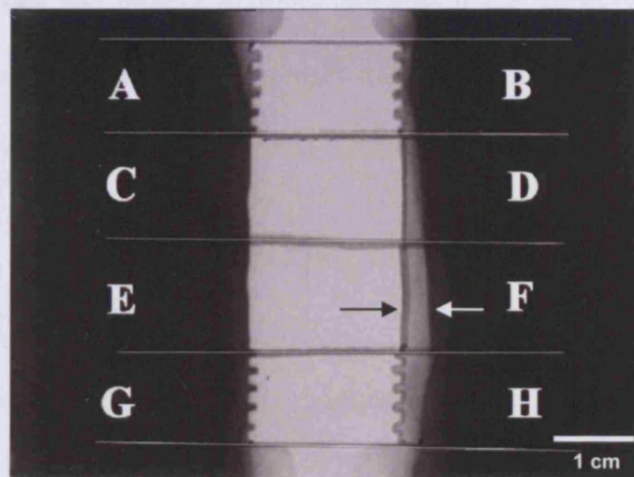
Sample radiograph (2×10^6 BMSCs/collar, ML view) divided into eight regions (A-H) for quantitative analysis of new bone formation adjacent to implants. The pedicle of bone grown along the length of the implant shaft is indicated with a white arrow. A radiolucent line between the pedicle of bone and the implant is shown with a black arrow.
